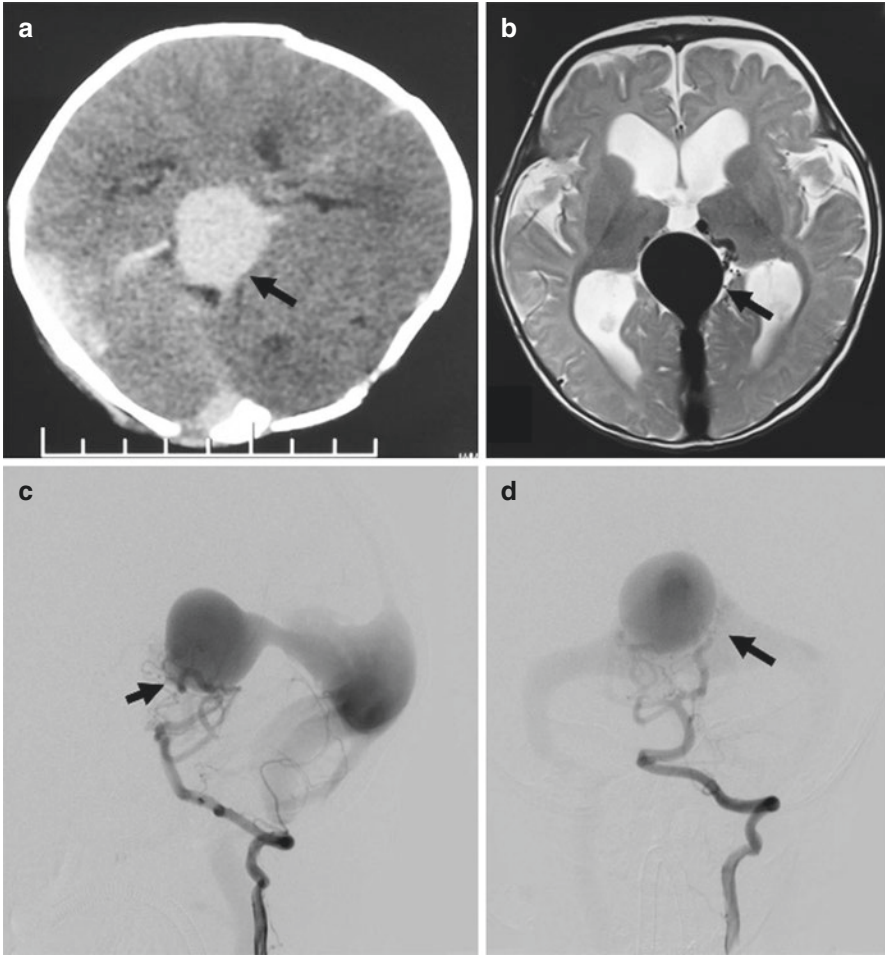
An example of a mural VGA in a 4-month boy. (a), CT show a round mass in the quadrigeminal cistern behind the posterior edge of the third ventricle (Black arrow). (b), MRI, T2-weighted, axial view, revealed a large area of flow void along the course of the deep vein (Black arrow). (c), left vertebral artery angiogram, lateral view. (d) left vertebral artery angiogram, anteroposterior view. Showing the VGA supplied by the bilateral posterior choroidal arteries with out-flow stenosis (Black arrow)
